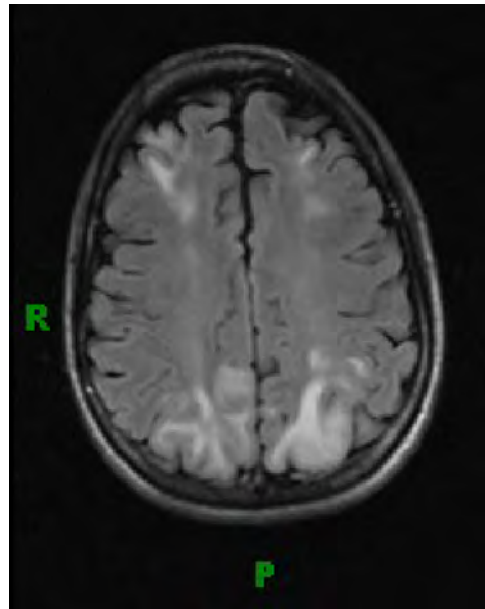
Brain magnetic resonance imaging with and without gadolinium revealed interval development of extensive signal abnormality that was characteristic of PRES.
